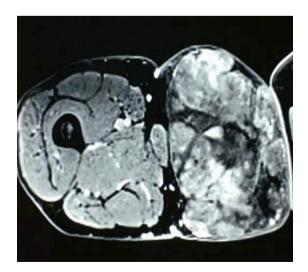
MRI axial section in injected T1.
